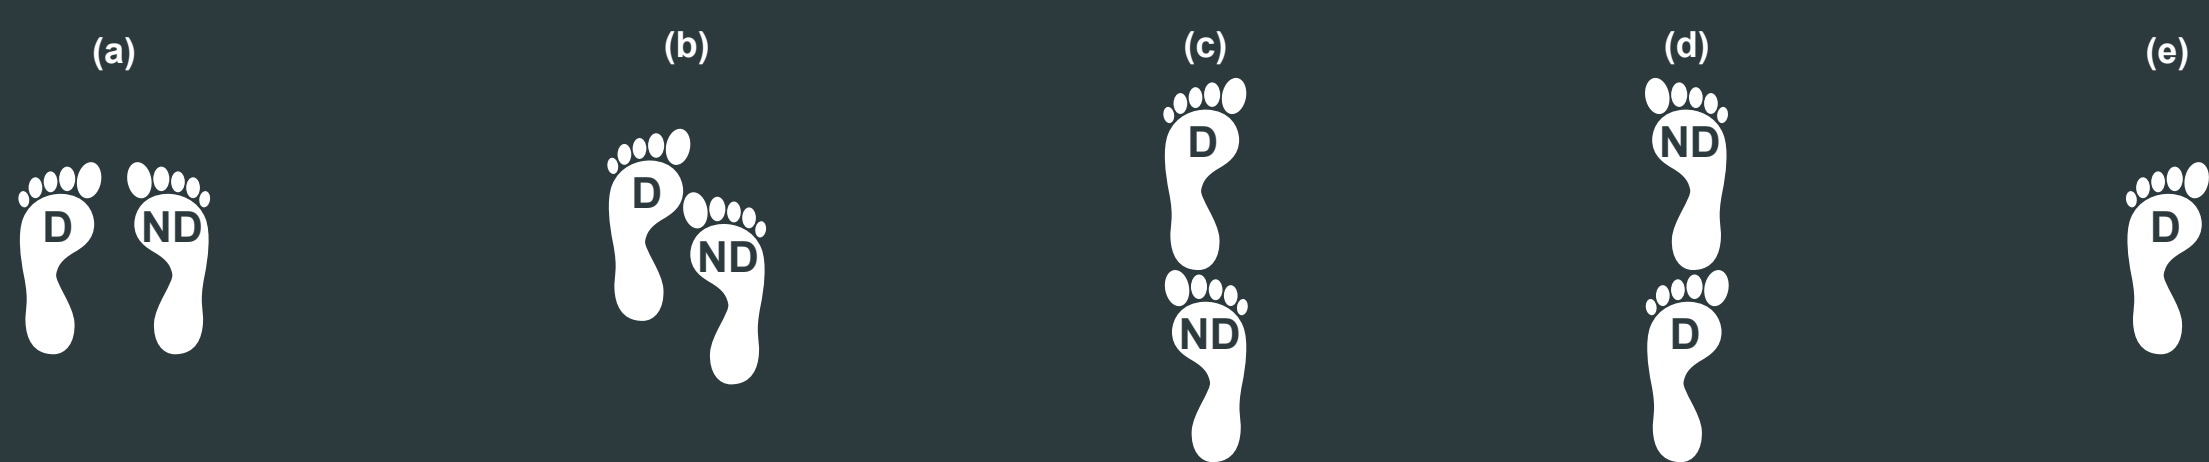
The five different foot positions used: (a) PS, (b) SET, (c) TAN, (d) CTA, and (e) SL. The leg dominance is marked by D (dominant leg) and ND (non-dominant leg). Note that the m-l dimension in PS (a) equals that of the hip-width.
